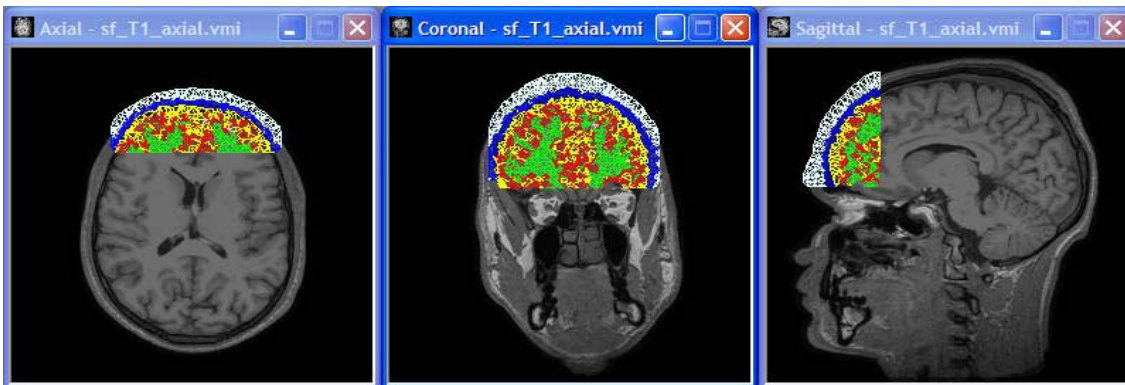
3D T1-weighted structural MRI of a human head with actual mesh geometry
